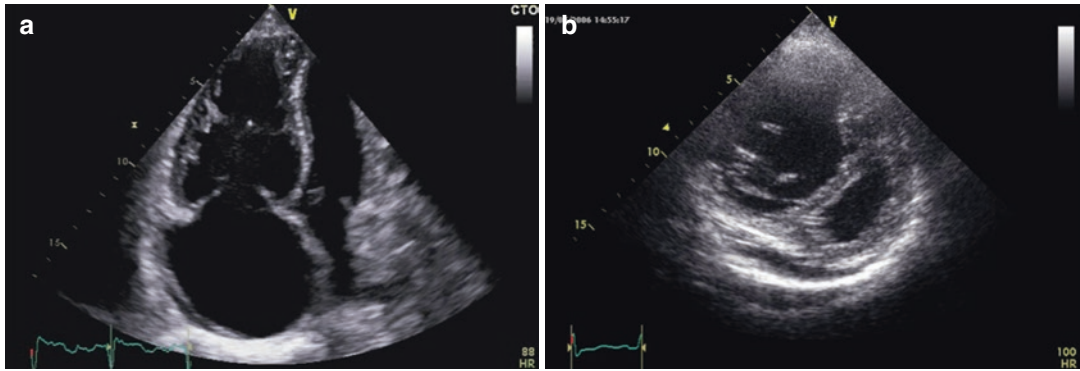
Transthoracic echocardiography, 2D examination: indirect signs of pulmonary hypertension based on the ventricles with RV dilation an RV/LV ratio >1 in apical 4-chambers view (a) and flattening of the interventricular septum with left ventricular eccentricity index >1.1 in parasternal short axis view (b)
